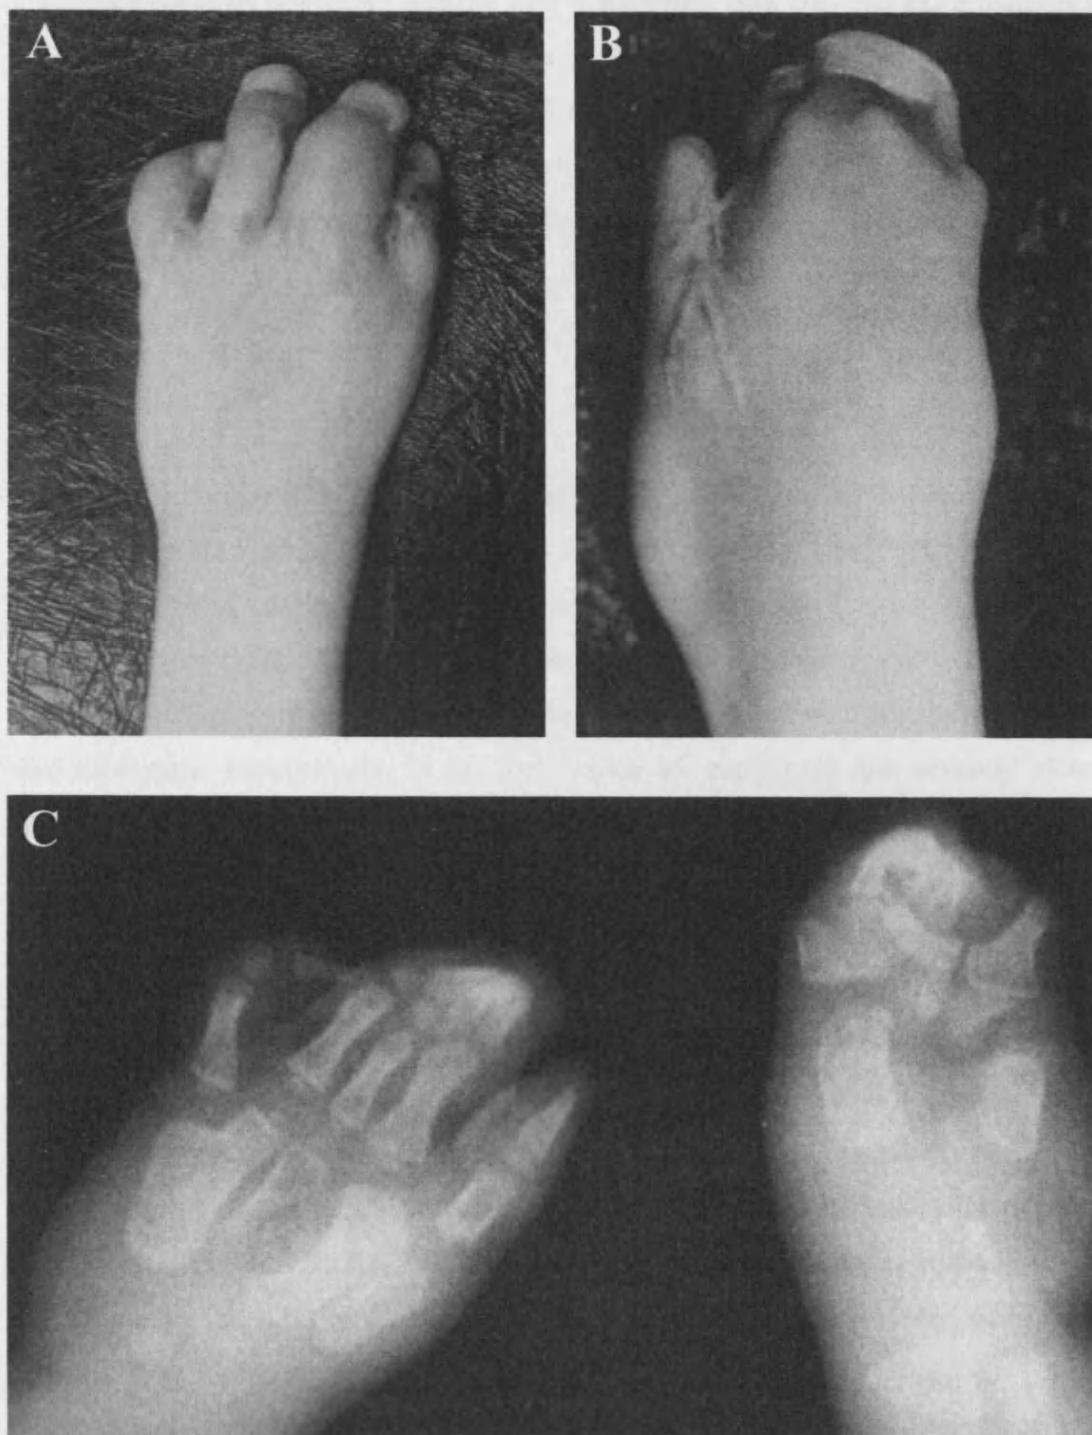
Clinical photographs and radiograph of the hands of patient II.1 from Family E. There is soft tissue syndactyly of the fingers and fusion of some of the nails, more severe on the right (B) than on the left (A). Many of the phalanges and metacarpals are malformed, fused or missing, especially on the right, where the phalanges form a disorganized mass of bone.
